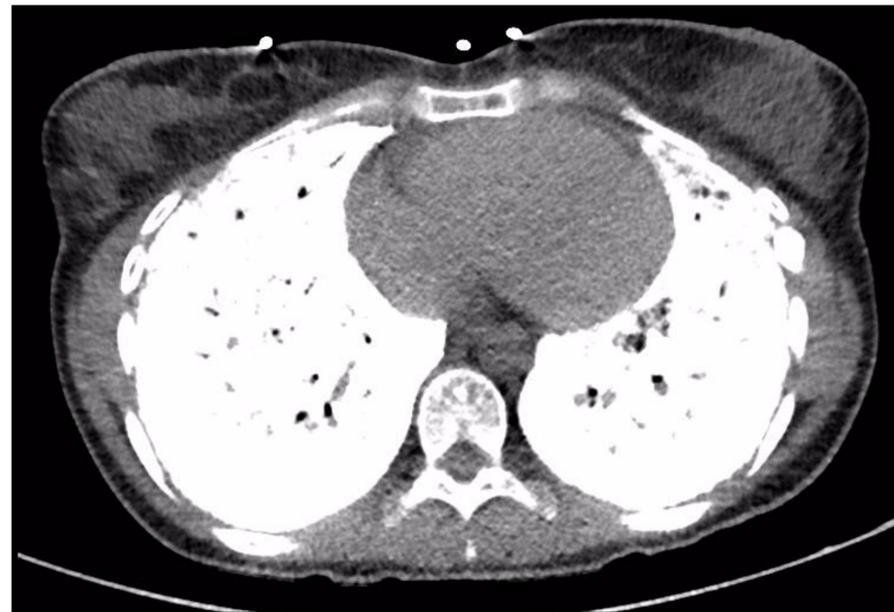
High Resolution Chest CT Axial View
